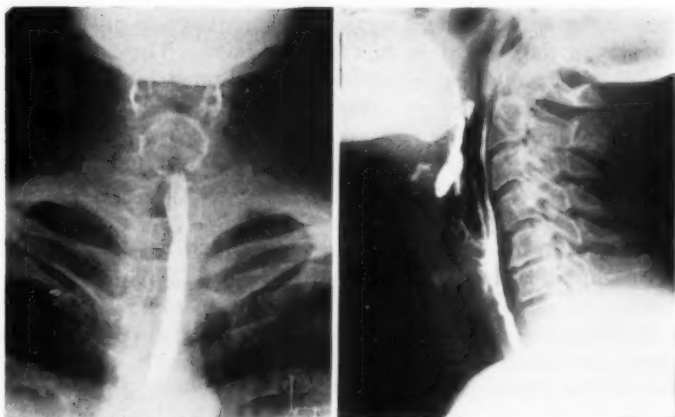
Post-operative antero-posterior and lateral roentgenograms.
